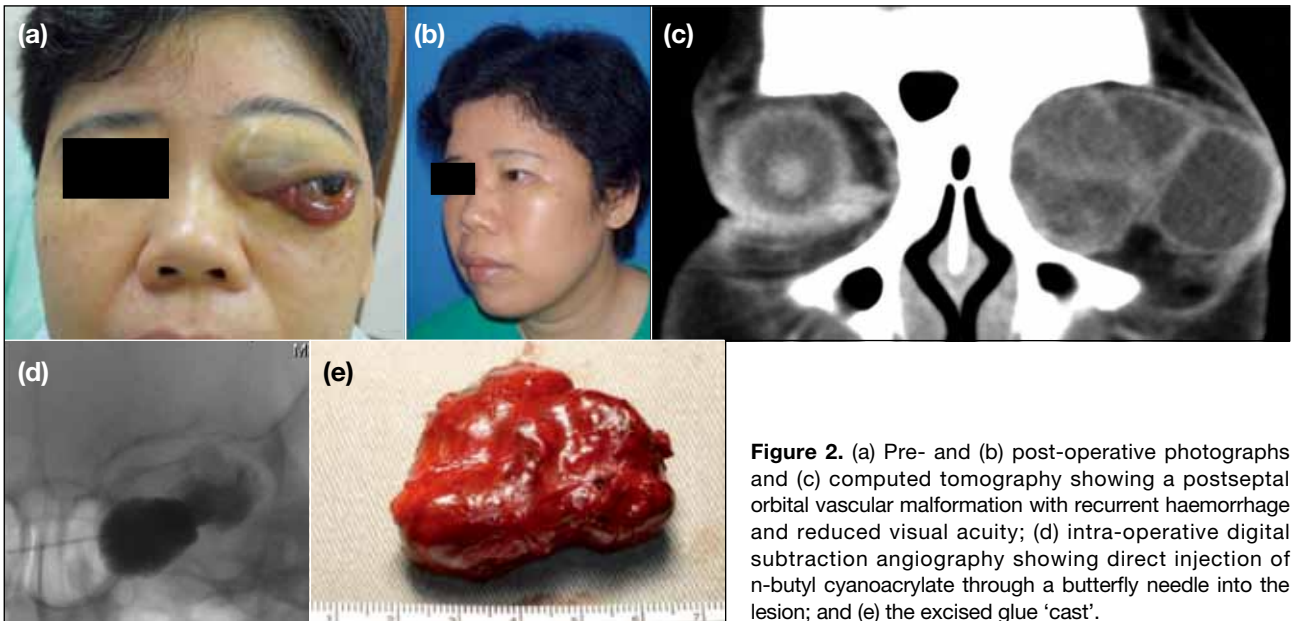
(a) Pre- and (b) post-operative photographs and (c) computed tomography showing a postseptal orbital vascular malformation with recurrent haemorrhage and reduced visual acuity; (d) intra-operative digital subtraction angiography showing direct injection of n-butyl cyanoacrylate through a butterfly needle into the lesion; and (e) the excised glue 'cast'.
